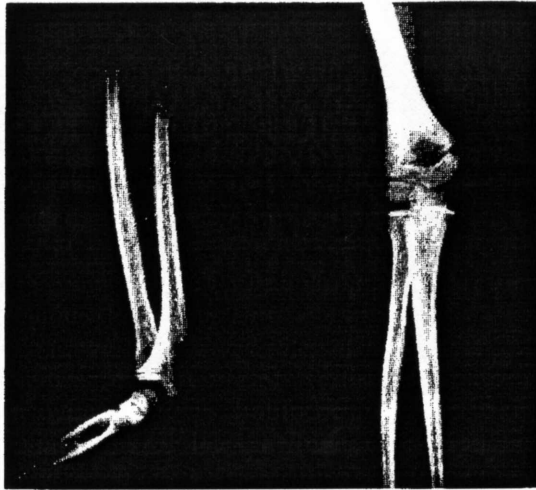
Roentgenogram showing minimal to no displacement.
